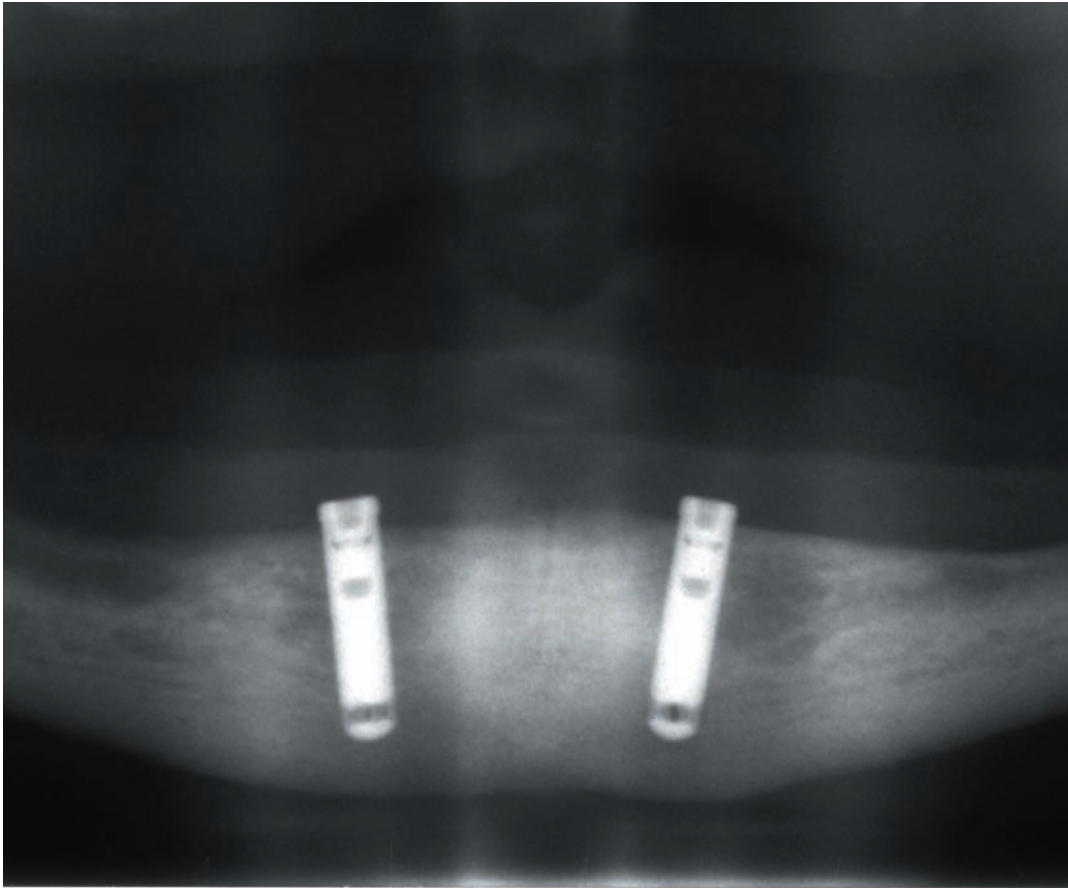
Panoramic radiograph taken one week postoperatively. Fixed reference points are indicated with arrows.
